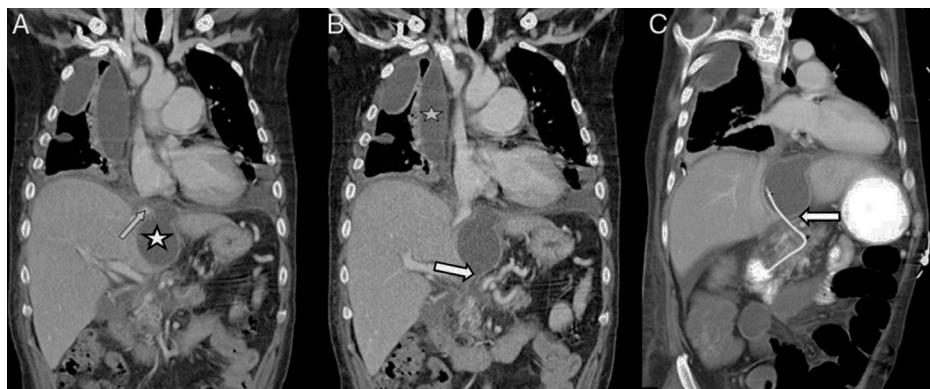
(A and B) Coronal reconstructions of CT in a 47-year-old patient with a history of chronic pancreatitis complicated by a thoracopancreatic fistula. CT shows a loculated pleural effusion (star in B) connecting (arrow in A) with the pseudocyst (star in A), which in turn connects with the pancreatic duct (arrow in B). (C) Follow-up CT performed at 12 days, after ERCP and prosthesis placement (arrow in C), draining the pseudocyst and pleural collection via the pancreatic duct to the duodenum.
